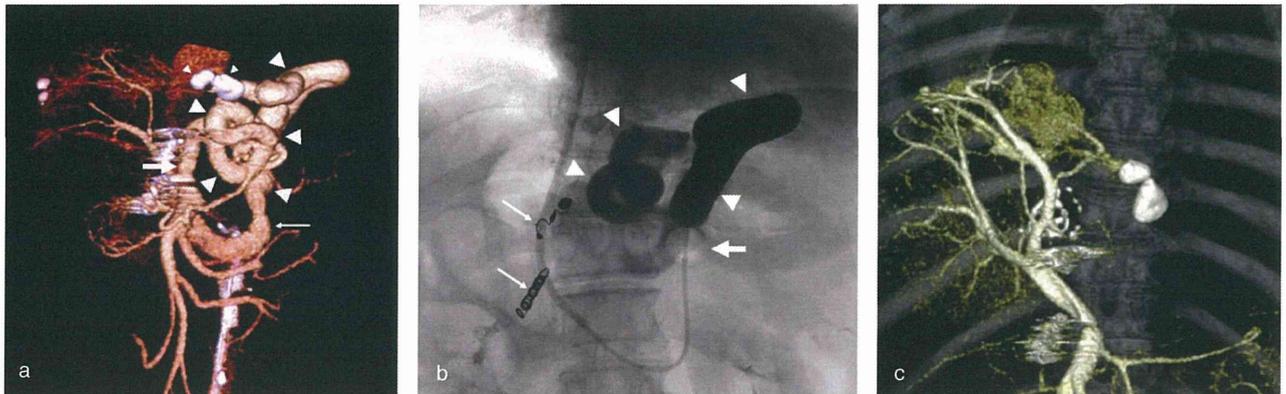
Percutaneous transvenous embolization (PTE) with 5% ethanolamine oleate iopamidol (EOI) for gastorenal (GR) shunts (patient no. 5). (a) 3-D image obtained by computed tomographic arterial portography via a superior mesenteric artery shows GR shunt (large arrowheads) from a right gastric vein (large arrow) to a left renal vein (small arrow). Small arrowheads indicate the calcified lymph nodes' swelling around a stomach. (b) Fluoroscopic spot image shows a total of 15 mL (0.29 mL/kg bodyweight) of 5% EOI injected from a 5-Fr balloon catheter (large arrow) via a right jugular vein into the GR shunt (arrowheads). Small arrows indicate microcoils at a right gastric and gastroduodenal arteries for hepatic arterial infusion chemotherapy using an implanted hepatic arterial port system for hepatocellular carcinoma treatment, which was removed during PTE. (c) 3-D image obtained by intravenous contrast-enhanced CT 27 months after PTE shows no appearance of the GR shunt.
